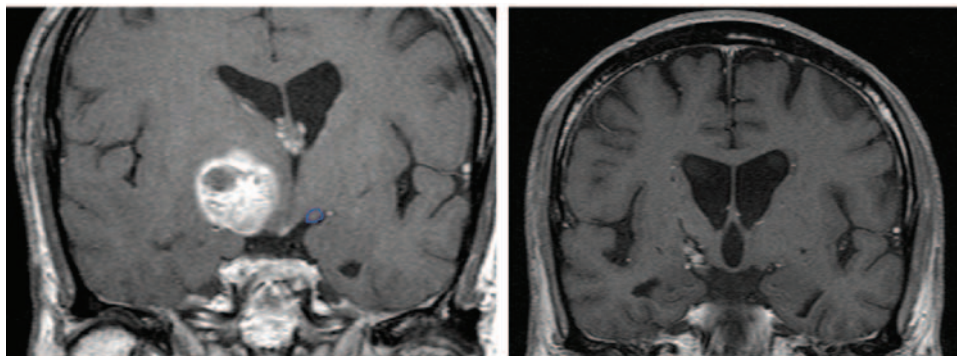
Left:* Magnetic resonance image revealing a large basal ganglia metastasis from lung carcinoma before treatment. *Right:* Rapid shrinkage of the tumor is seen at 3 months after GKS.
